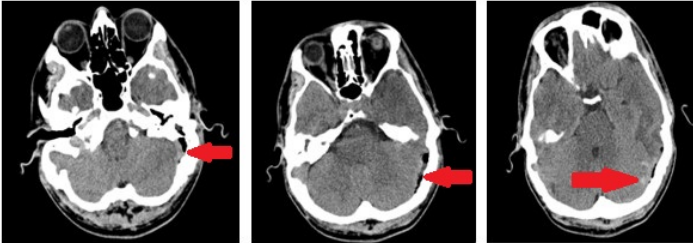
Brain CT scan when pneumocephalus is detected
